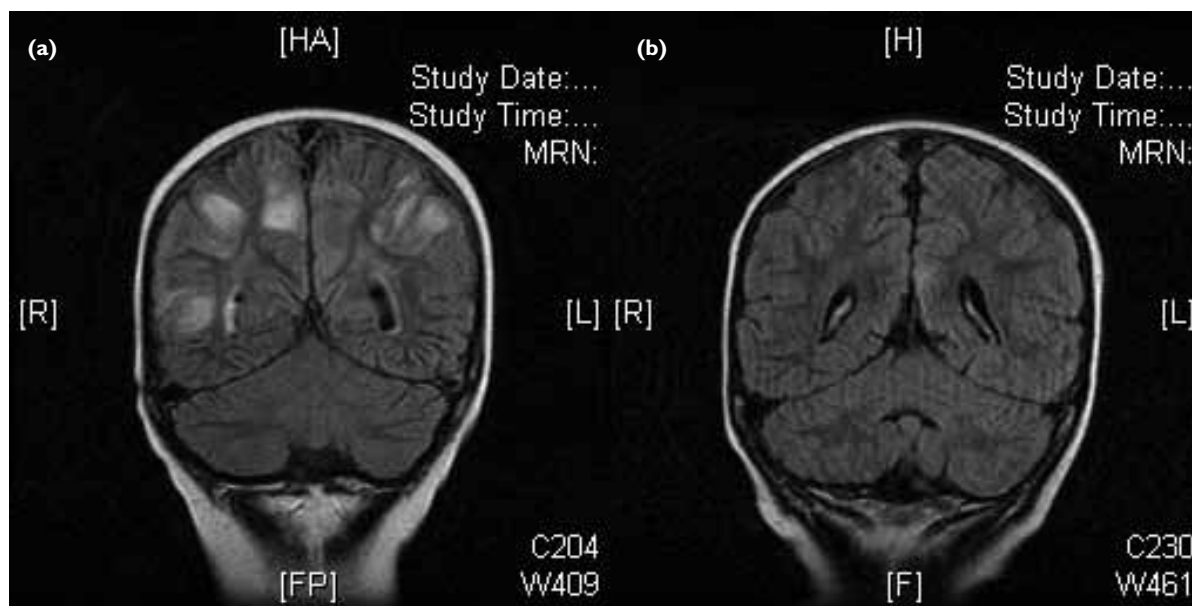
Magnetic resonance images of the brain in patient No. 2
